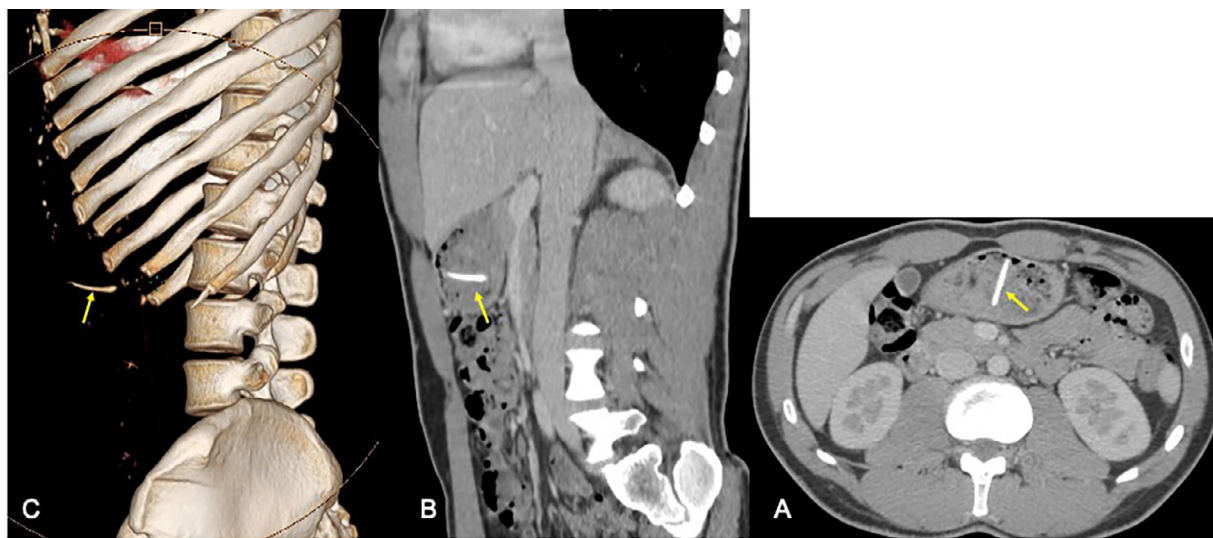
CT scan of the abdomen in portal phase, with axial (A), sagittal (B) and VRT (C) reconstructions, showing a linear calcified high-density object in the antrum (yellow arrows). Note in the VRT image the sharp edge of the bone by the front stomach lining, which was causing its erosion and bleeding.
